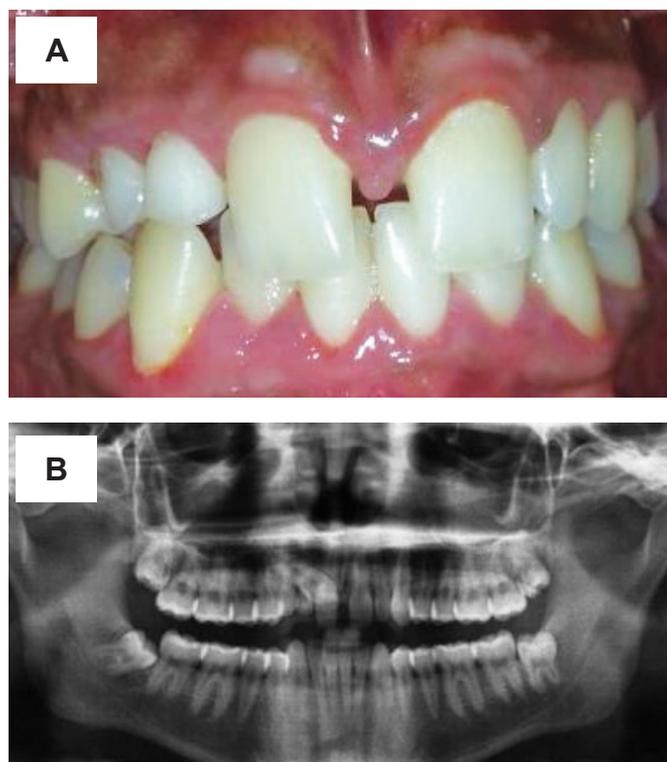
A: Pretreatment intraoral photograph: (frontal view) B: Initial panoramic radiograph.
